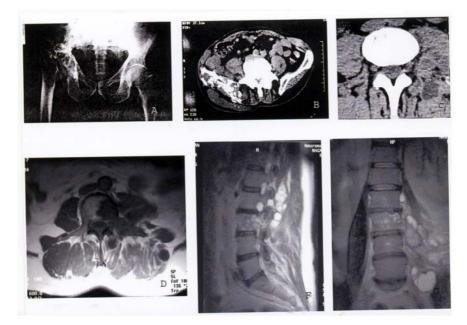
A) plain film of the pelvis showed a "tumour-like" lesion of the right iliac bone; B) CT obtained at the iliac crest demonstrated destruction of the right iliac bone with a multiloculated small cystic mass partly surrounded by sclerotic changes of the bone; C) CT at lumbar vertebra, hypodense oval soft – tissue lesions within left paravertebral muscles; D) T1 weighted image: hyposignal of the L3 vertebra with affection of the body and pedicle of the vertebra. Round lesion in muscle-hydatid cyst; F) and G) T2 weighted images, sagittal and coronal, of the lumbar spine with paravertebral muscle. High signal intensity can be seen in the lesion of the vertebra, and a lot of cysts within the paravertebral soft tissue.
